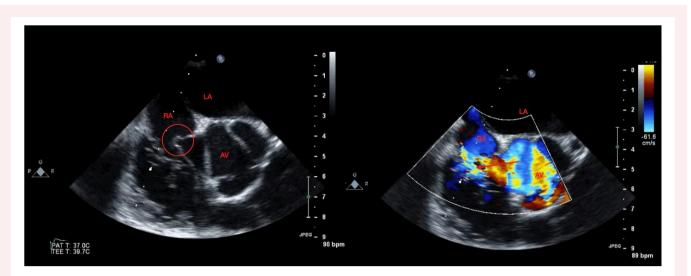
(A–B): A TEE mid-oesophageal short axis view at the level of the aortic valve showing the aneurysmal outpouching (windsock appearance) of the non-coronary sinus of valsalva aneurysm (circled) (A). Doppler image showing a regurgitant flow from the non-coronary sinus to the right atrium (arrow) (B). AV, Aortic Valve; LA, Left Atrium; RA, Right Atrium.
